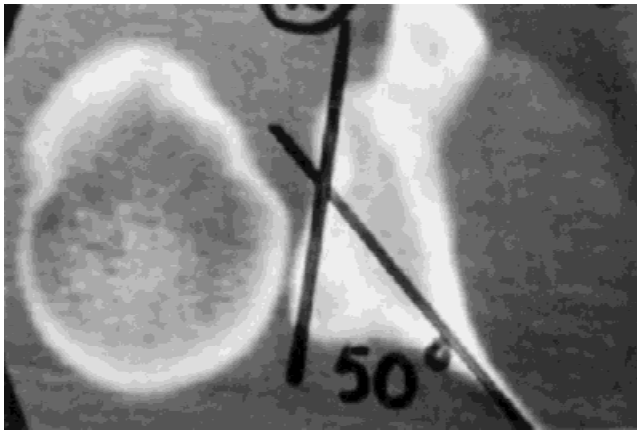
CT scan of a patient with posterior glenoid hypoplasia with increased glenoid retroversion.
